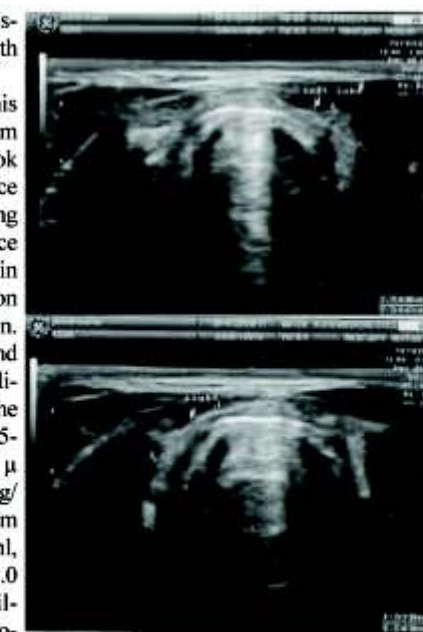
Sonography of the right and left thyroid lobes showing short dimensions of the thyroid gland
